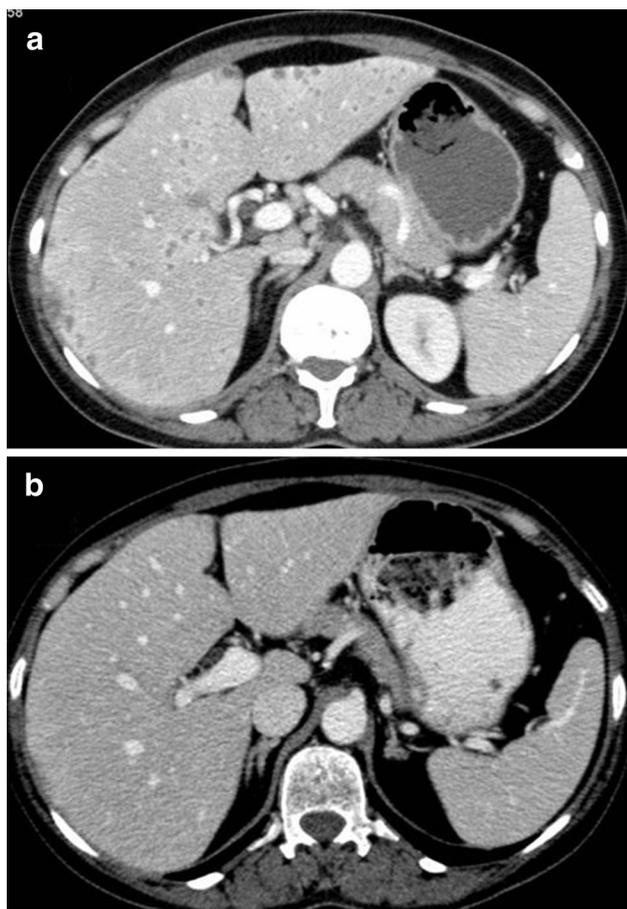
a Contrast enhanced abdominal computed tomography revealing diffuse hypodense infiltrative lesions in the liver representing microabscesses. b Decrease in the abscess sizes after prednisolone therapy
